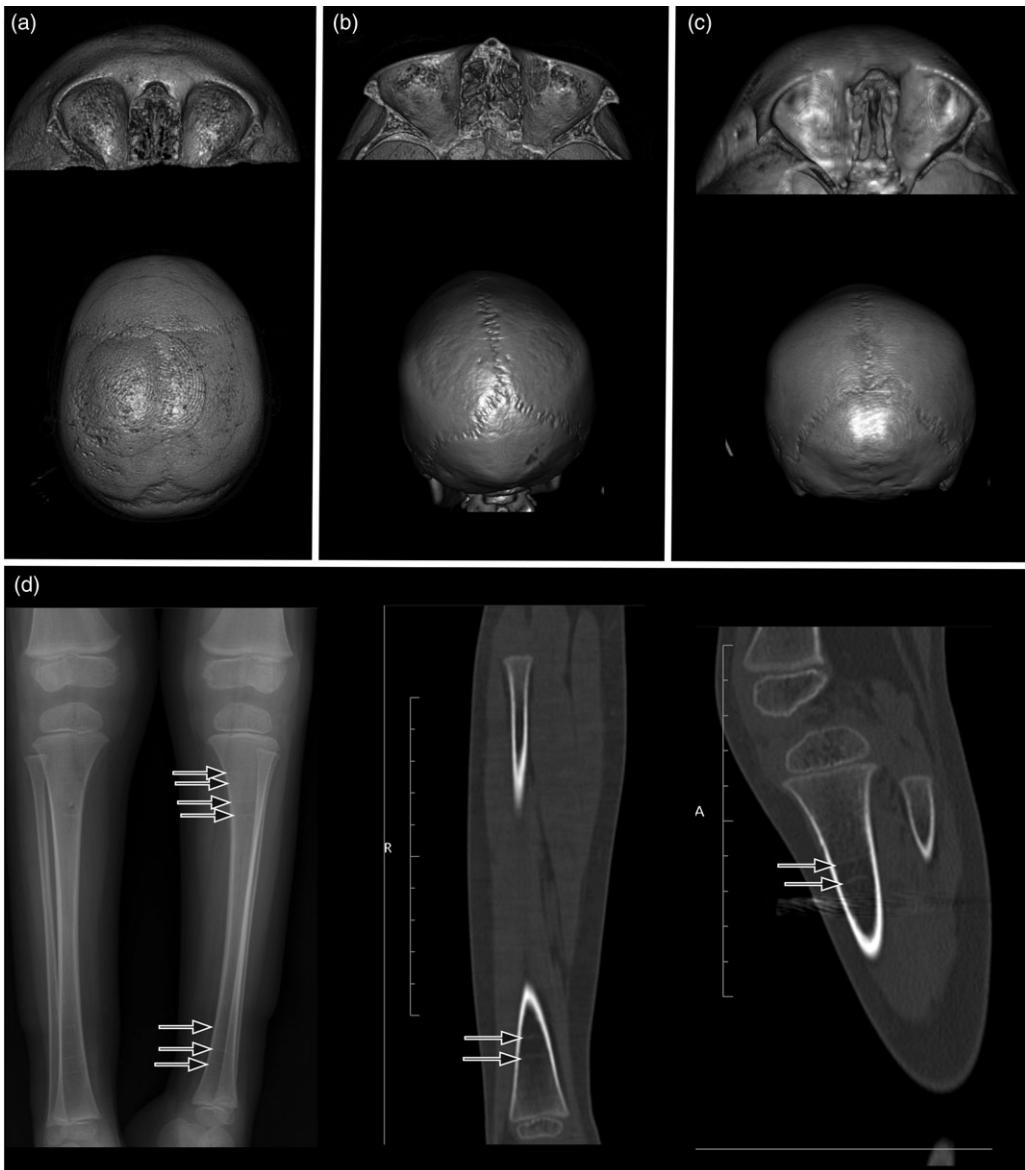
PMCT images of porous cranial lesions of the orbit (cribra orbitalia) and vault (porotic hyperostosis) and Harris lines. (a) Orbital and vault lesions present with marrow expansion; (b) Orbital and vault lesions present without expansion; (c) absence of PCLs; (d) Harris lines (marked with arrows) as observed in a single individual. The far-left image is a radiograph, and the others are from PMCT. Harris lines are observable in both radiographs and PMCT.
